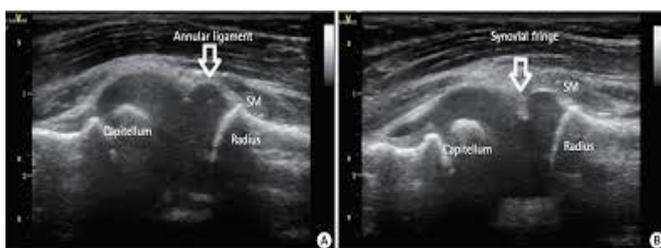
Ultrasound image showing synovial fringe getting inside in the “Pulled elbow”
